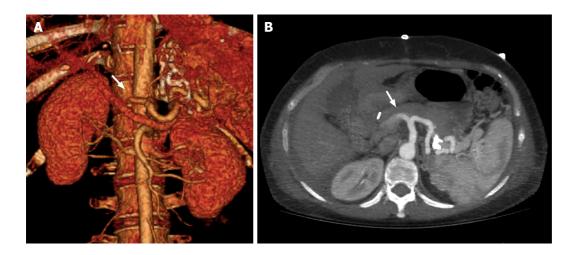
Computed tomography angiography evaluation of hepatic artery thrombosis in liver graft. A 51-year-old woman on postoperative day 7 after a liver transplant. A: Axial abdominal computed tomography angiography (CTA) images at maximum intensity projection (white arrow); B: Coronal 3D volume rendering CTA reconstruction showing absence of vascular opacification of vessels distal to occlusion of the hepatic artery (white arrow).
